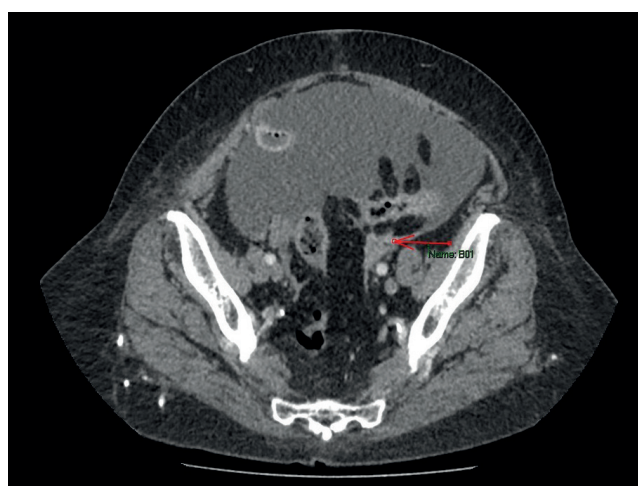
Post-contrast CT in the venous phase, axial section through the right adnexa – shows an irregular contour with ascitic fluid noted anteriorly.
